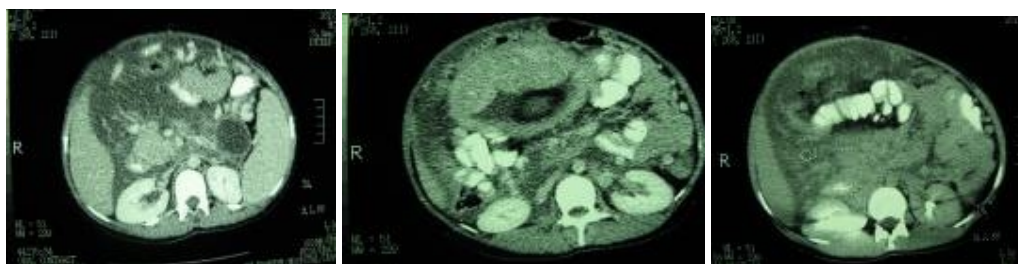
Features of patient's CT scan
